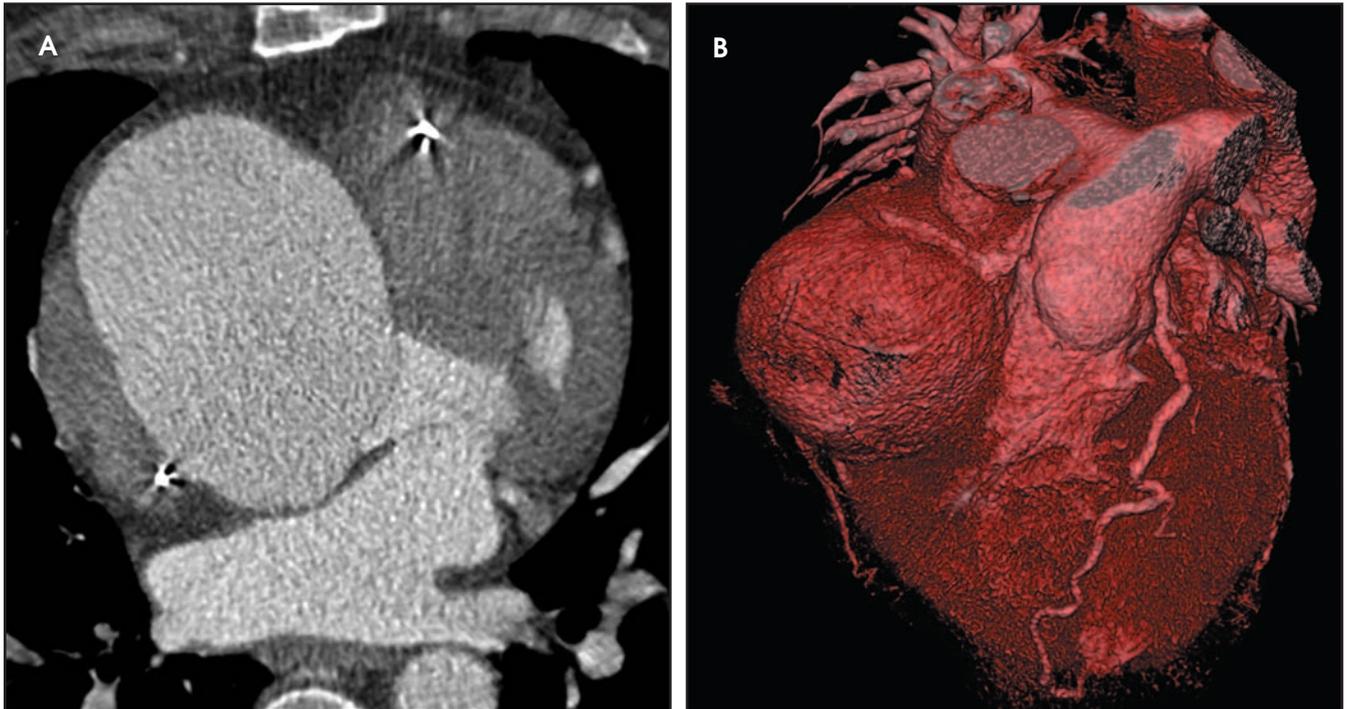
A 53-year-old patient with an approximately 10-cm aneurysm of the aortic root. While cardiac catheterization could not safely be performed, (A and B) coronary CTA visualized the aneurysm and demonstrated normal coronary arteries.
